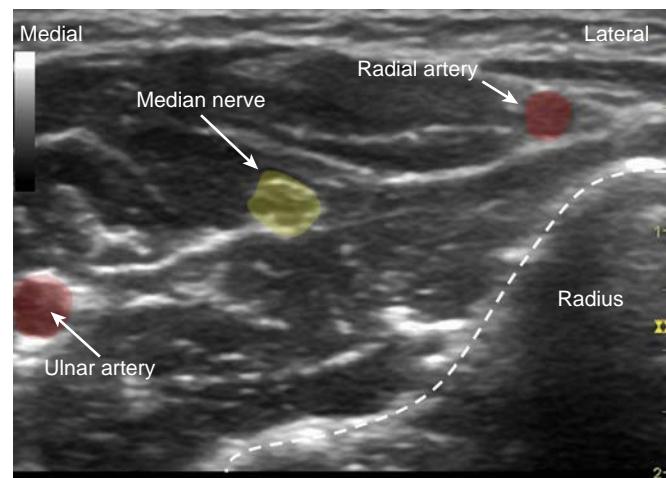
Ultrasound view of median nerve at the midforearm.
